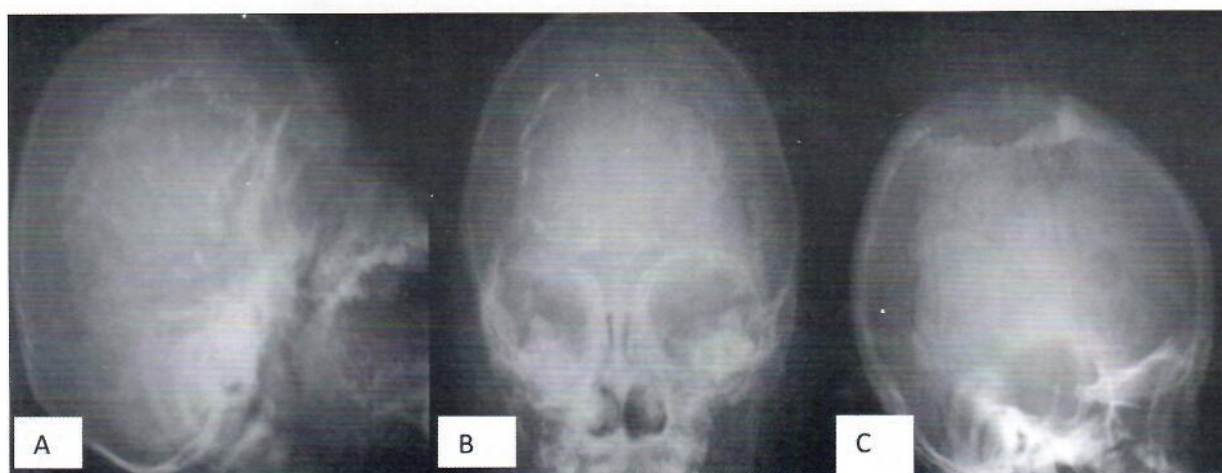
Plain radiograph of the skull showing intracranial calcifications (A&B). A Lateral plain radiograph of the skull showing destruction of the parietal bone at the vertex consistent with a metastatic bone lesion ©.
